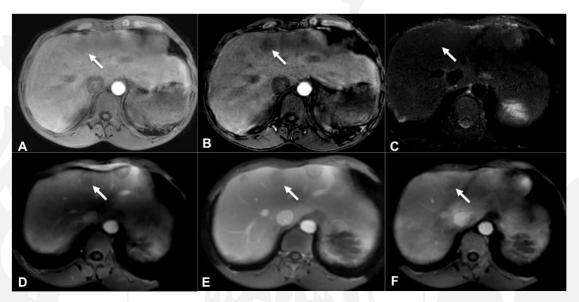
38-year-old woman with HNF1α-mutated HCA (white arrow). MRI. In-phase (A) and opposed-phase (B) T1-weighted images show a strong and homogenous signal drop of due to marked fat content. (C) On respiratory-triggered fat-suppressed turbo spin-echo T2-weighted imaging, the lesion is isointense compared to the surrounding liver. On 3D fat-suppressed GRE T1-weighted acquisitions after intravenous injection of gadoxetic acid, the lesion shows slight enhancement on arterial phase imaging (D). On portal venous (E) delayed phases (F) the lesion is hypointense.
